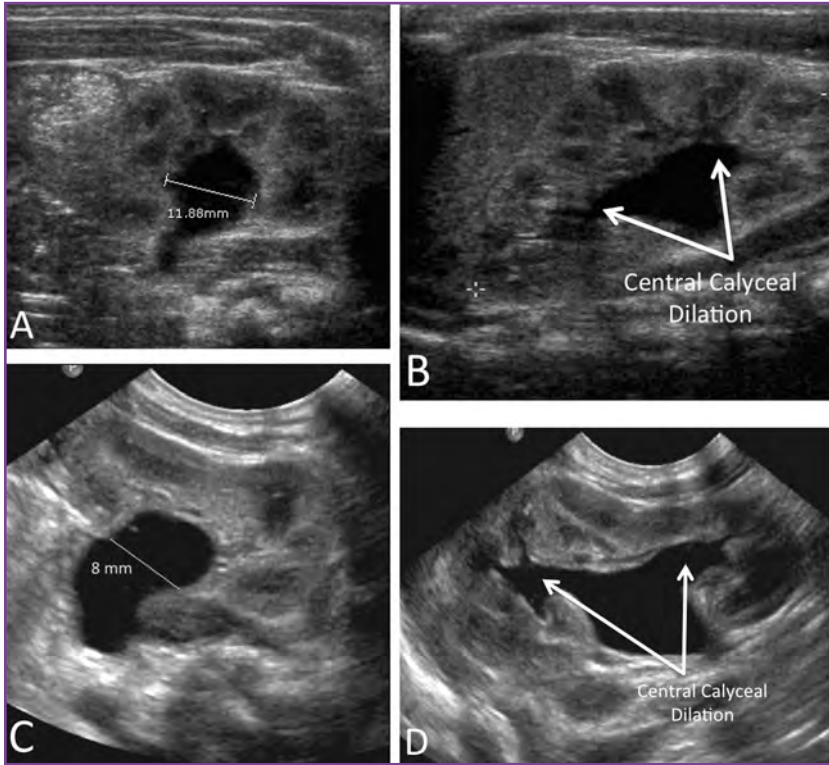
Urinary tract dilatation (UTD) grade P1 ultrasonographic (US) appearance.
